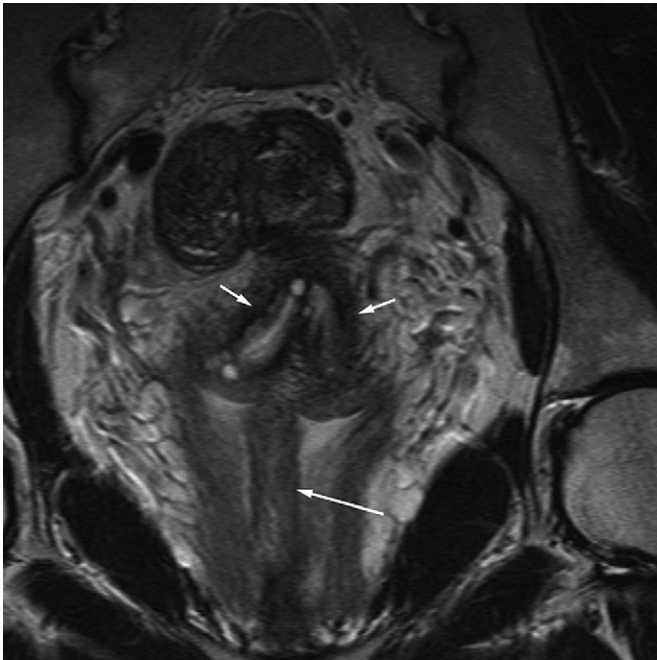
Coronal T2-weighted magnetic resonance image of the pelvis, demonstrating 2 separate cervixes (short arrows) and a thick, longitudinal vaginal septum (long arrow).
